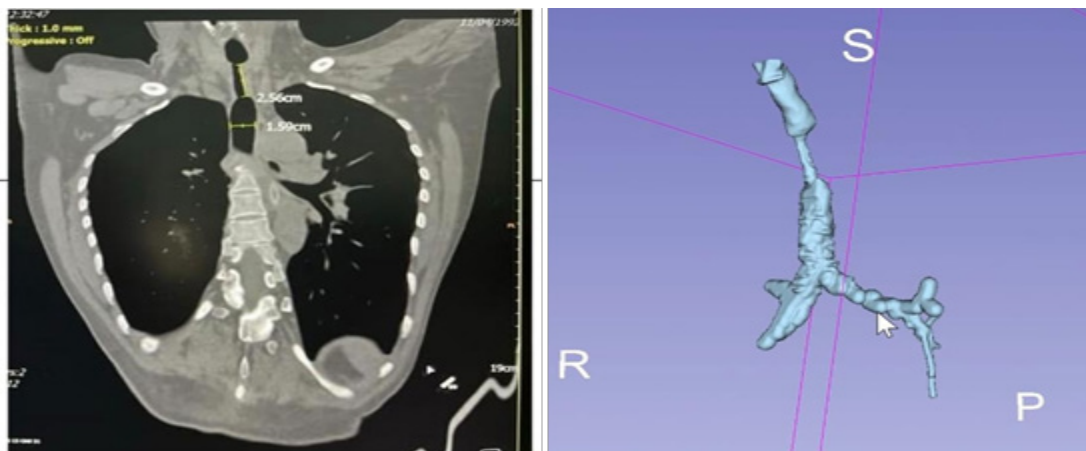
Thoracic computed tomography (CT) scan (left) with three-dimensional airway reconstruction (right) demonstrating tracheal stenosis at the T₁–T₂ vertebral level, with approximately 58% luminal narrowing over a length of 2.3 cm
